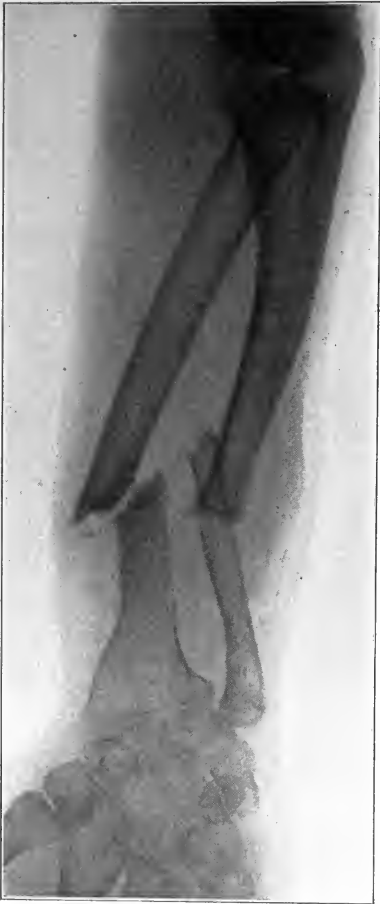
FRACTURE OF THE RADIUS AND ULNA. Failure of union. Note the atrophy in the upper end of the lower fragment of the ulna. In this case repeated operations in the effort to bring about union between the bones failed. Case of Dr. F. T. Brown. (X-ray by the author.)
